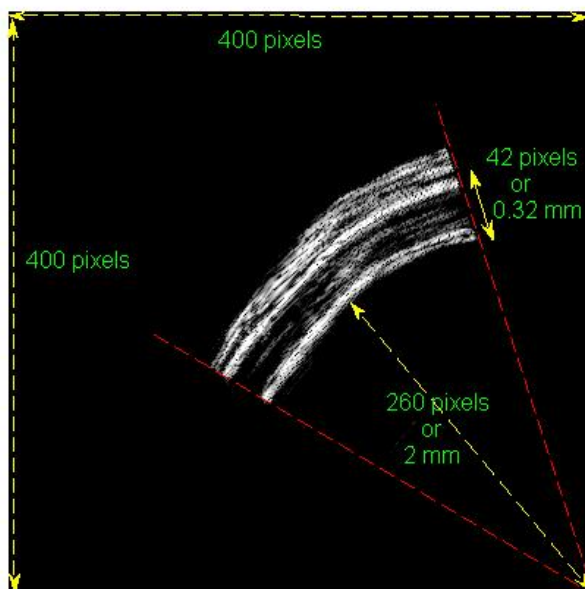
Ultrasound image of the coronary vessel wall at 90 mmHg
